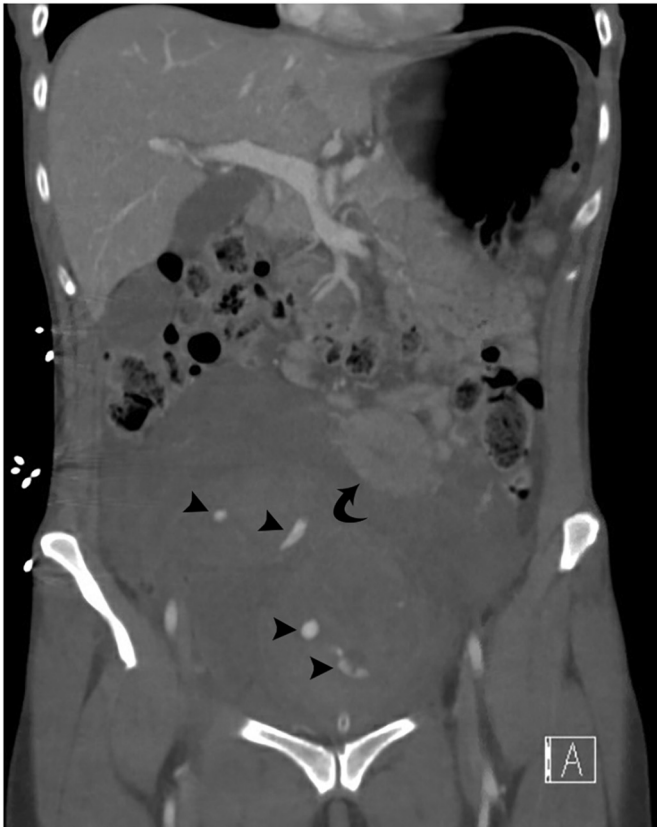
Coronal CT abdomen/pelvis. Large pelvic hematoma with active extravasation (arrowheads) and displacement of the uterus (curved arrow) superiorly
